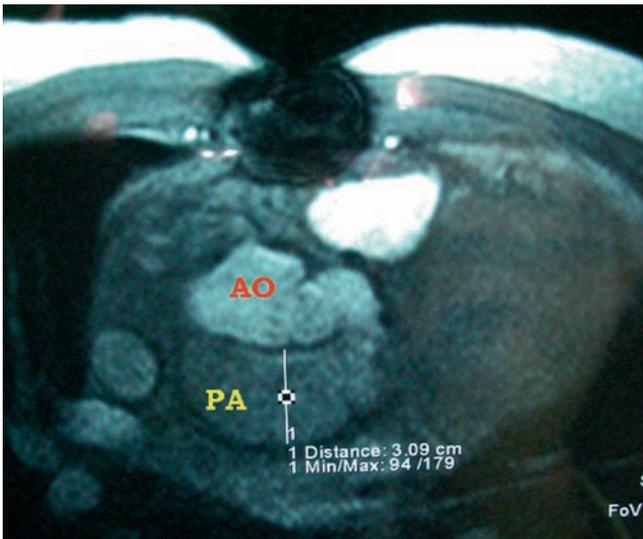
CT scan: Pseudo-aneurysm of the ascending aorta. PA pseudo aneurysm; AO aorta
